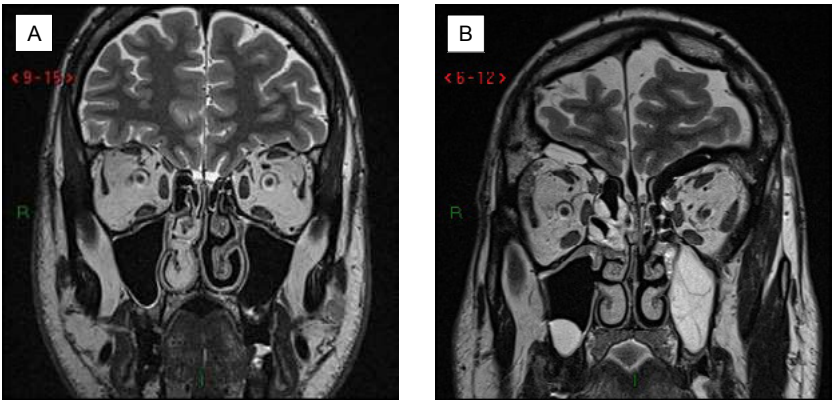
A: T2 coronal MRI showing the Olfactory bulb; B: T2 coronal MRI showing the olfactory bulb in CRS
